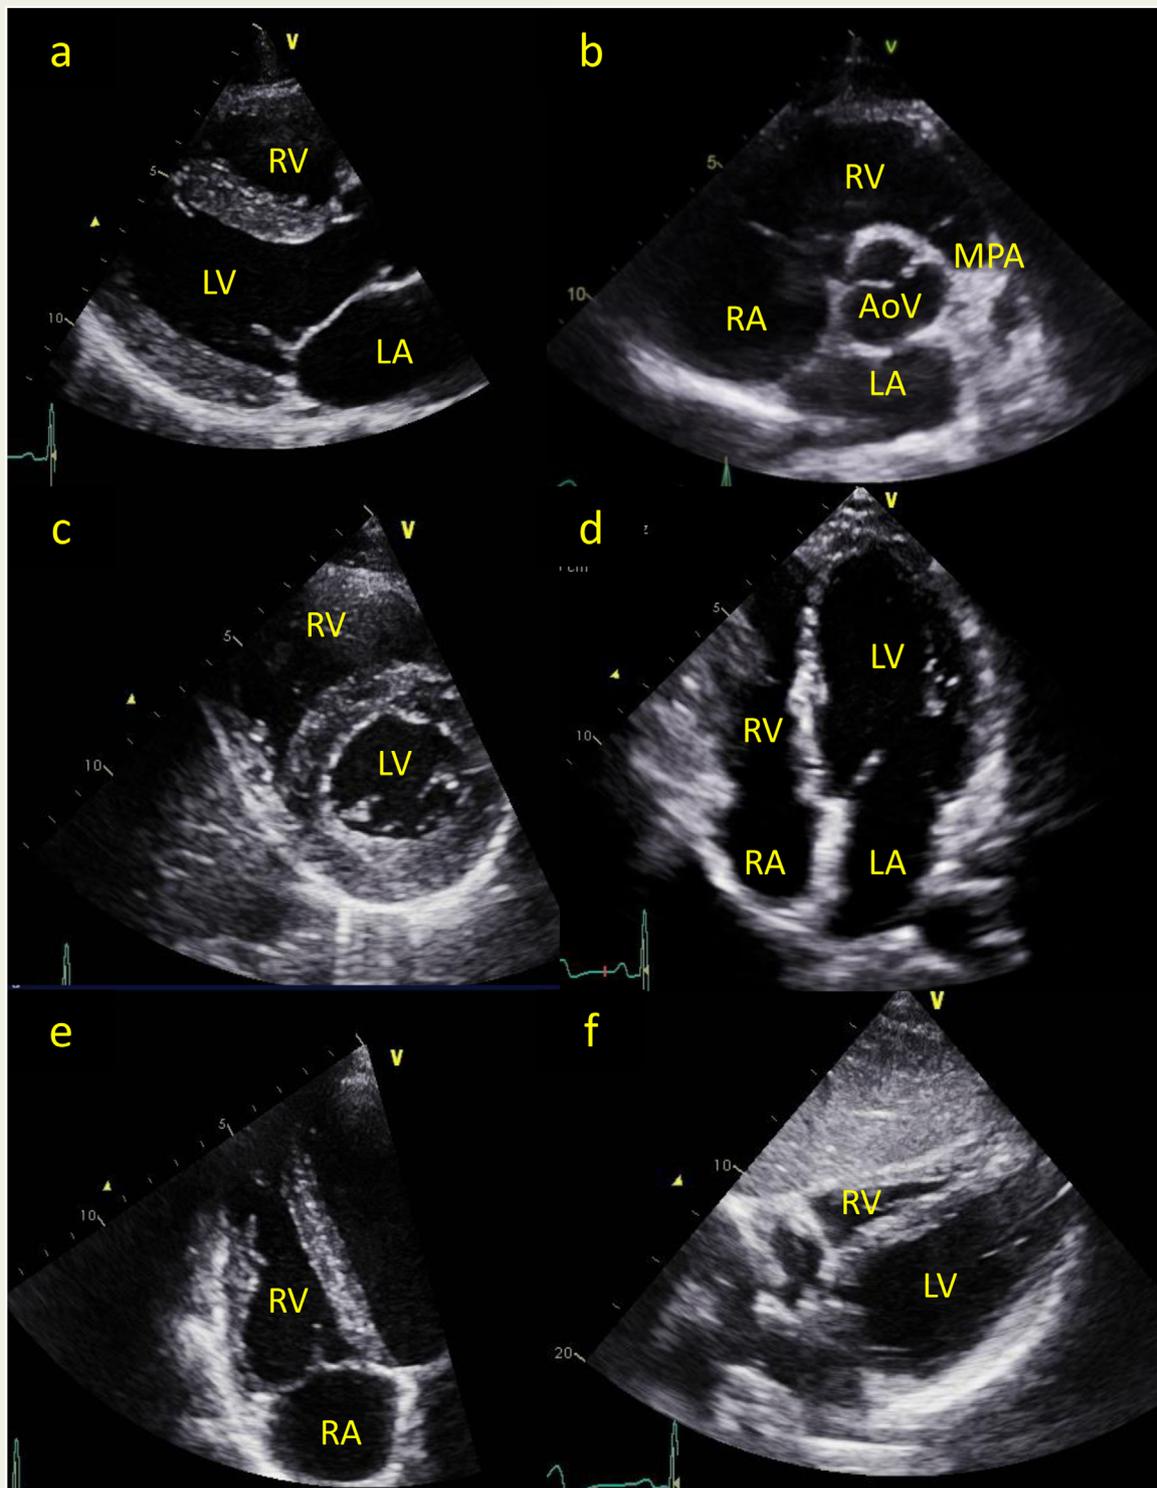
Appearance of the RV from common echocardiographic views.
